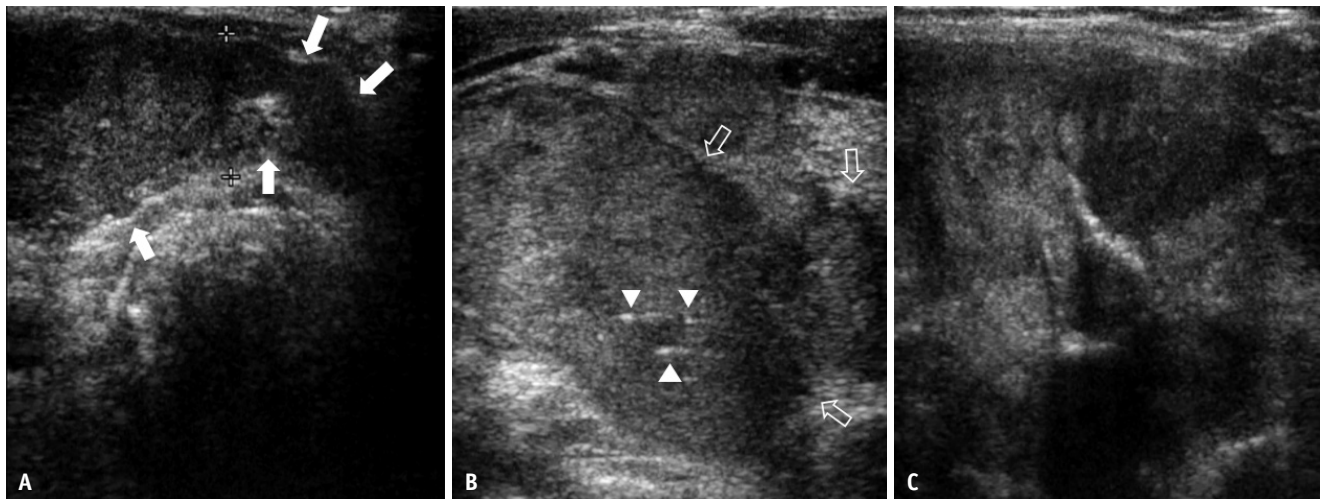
A 72-year-old female with widely invasive follicular thyroid carcinoma with mutant TERT. A-C: Transverse US images show a huge solid nodule with irregular margin (open arrows), hypoechoogenicity, heterogenous echogenicity, parallel orientation, lobulation (solid arrows), and punctate echogenic foci (arrowheads). This nodule was classified as K-TIRADS category 5 and ACR-TIRADS category 5. After surgery, the TNM stage was categorized as IV (T4aN0M1). Bilateral lung metastases were detected at the time of diagnosis and operative bed recurrences were diagnosed at 3 years after surgery. This patient expired 7 years after the surgery. US = ultrasound, TERT = telomerase reverse transcriptase, K-TIRADS = Korean-Thyroid Imaging Reporting and Data System, ACR = American College of Radiology, TNM = tumor, node, metastasis
